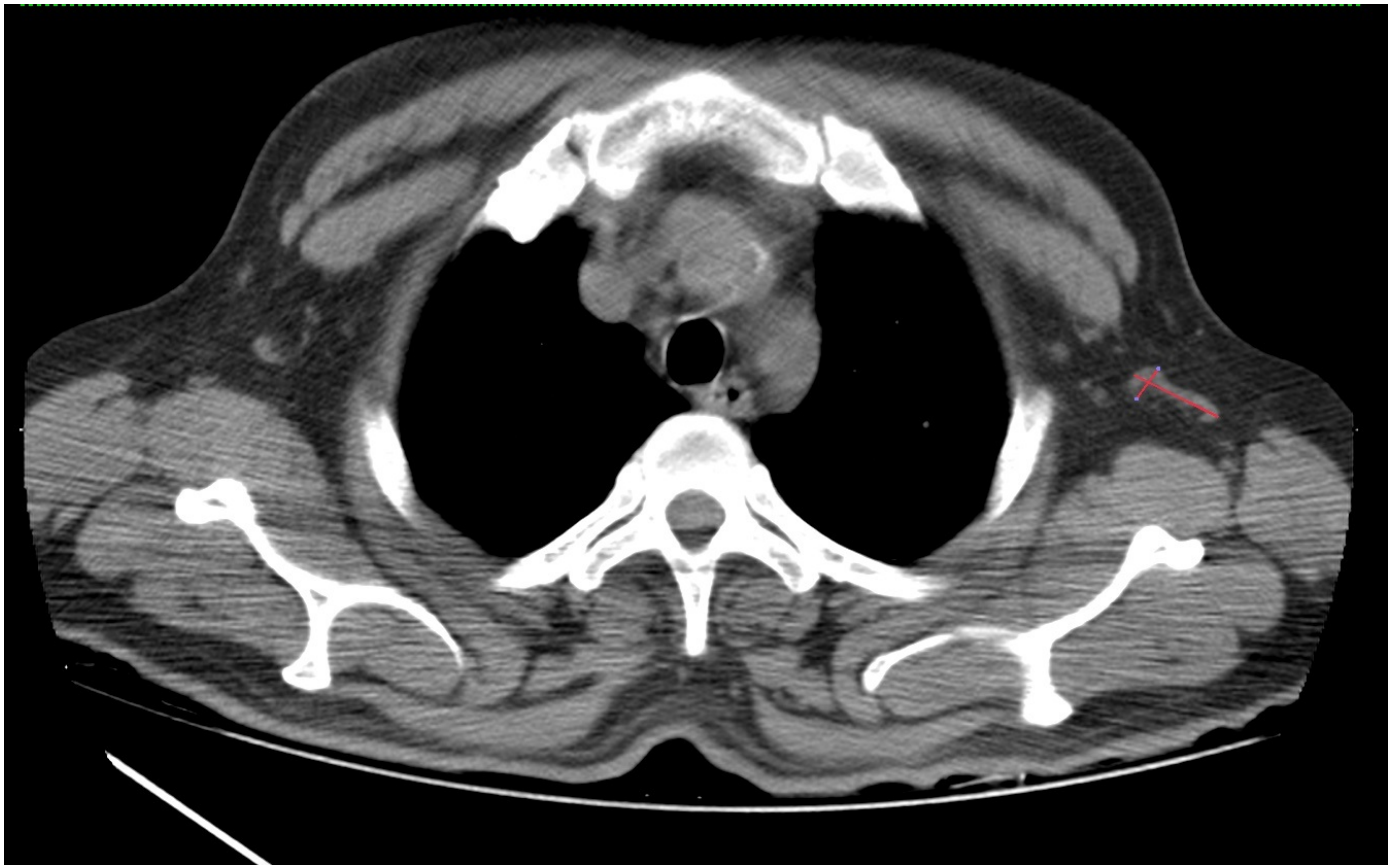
CT Chest non-contrast axial images: Measurement of left axillary enlarged lymph node post vaccination.
